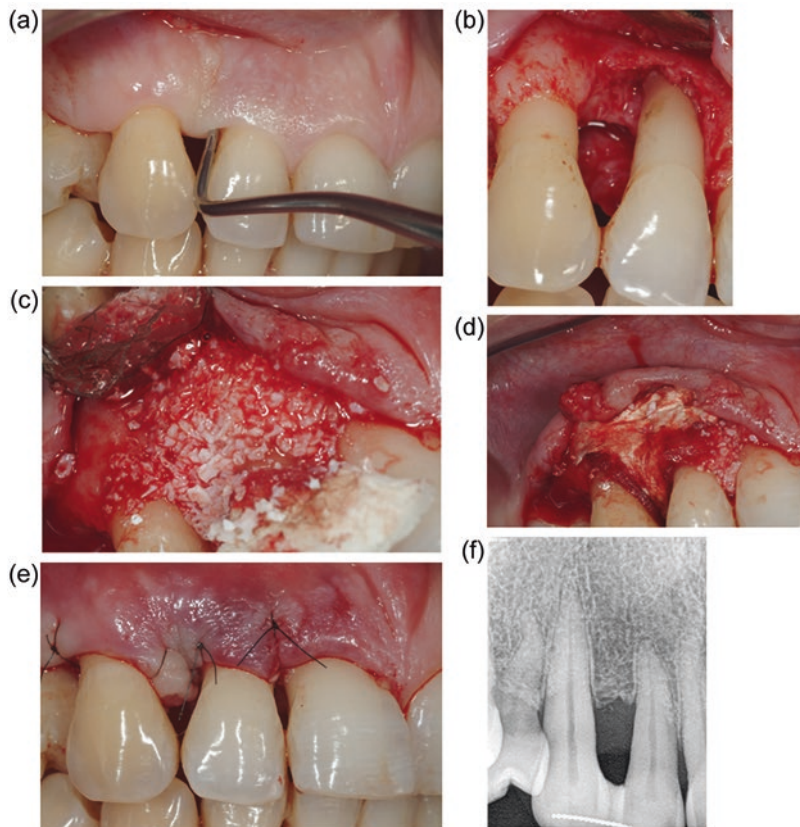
(a) Clinical evaluation of infrabony defect; (b) Intrasurgical situation; (c) bone graft insertion; (d) resorbable membrane adaptation; (e) suturation; (f) radiographic follow-up at 8 years
